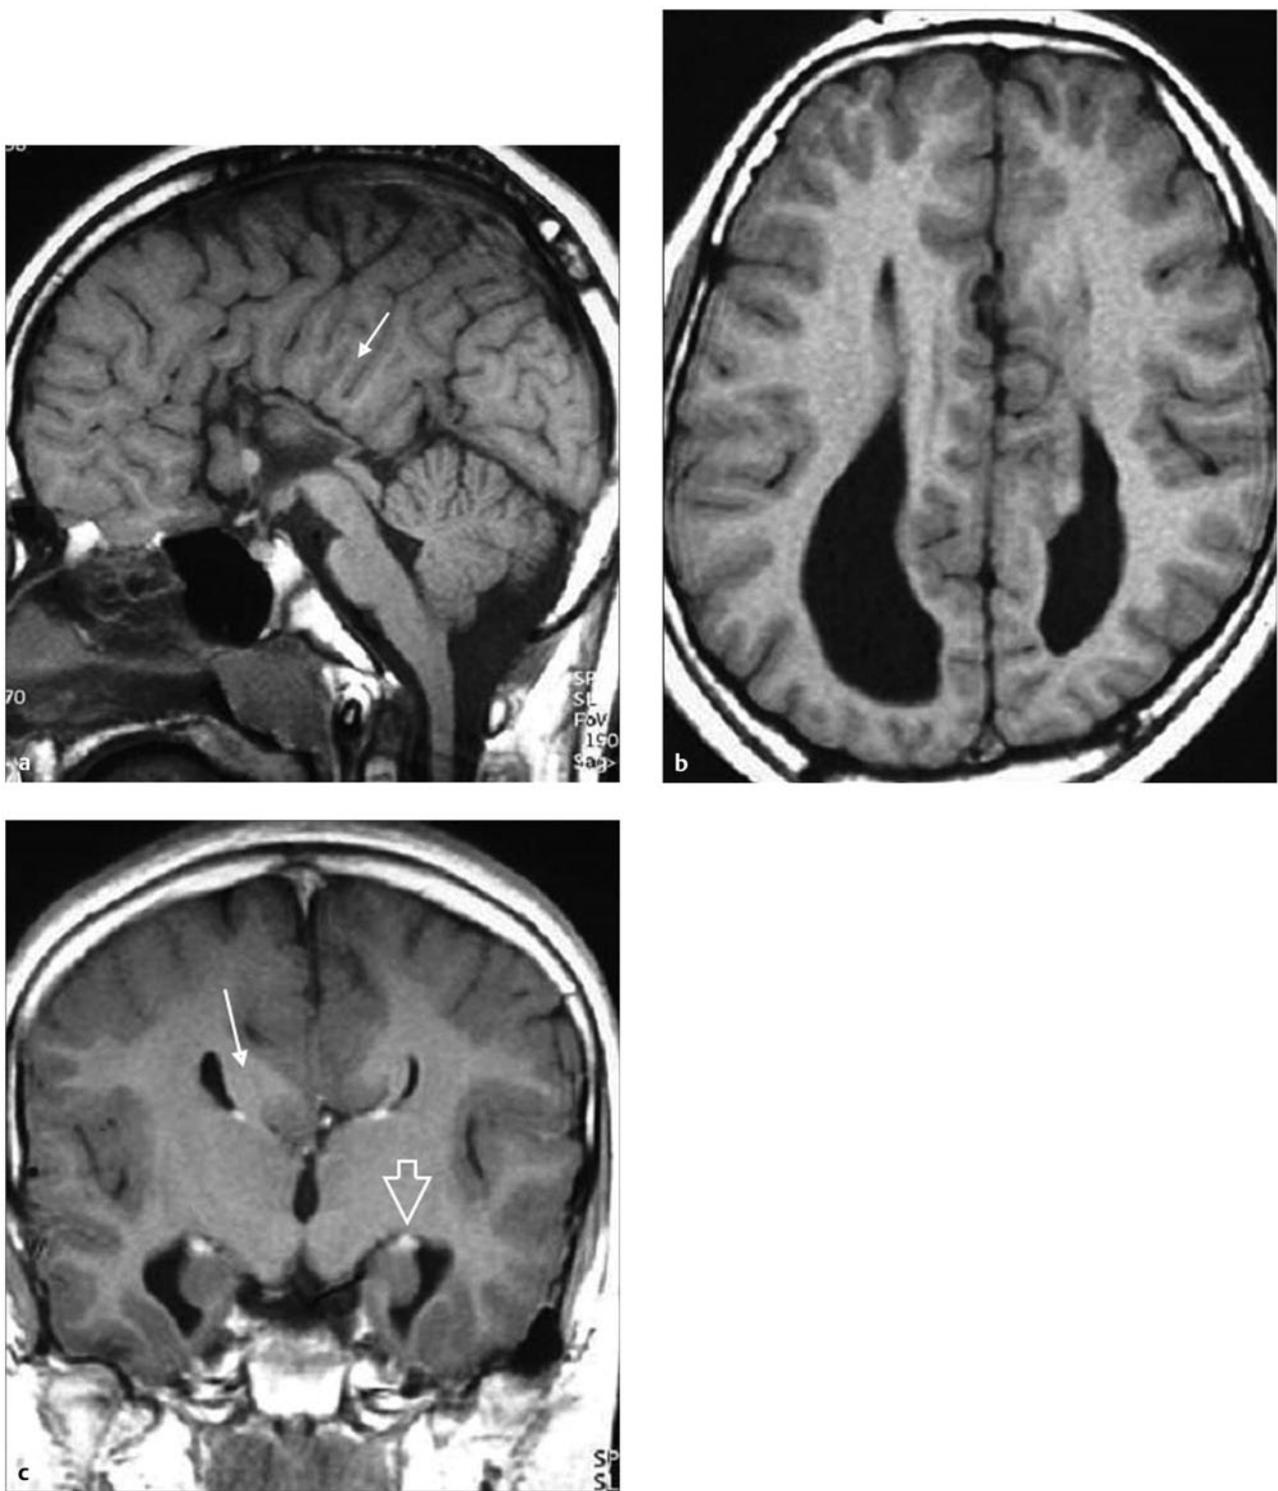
Dysgenesis of the corpus callosum. (a) Midsagittal T1-weighted magnetic resonance (MR) image shows absence of the body, splenium, and rostrum of the corpus callosum. The interhemispheric gyri are oriented radially (*arrow*). (b) Axial T1-weighted MR image shows widely separated and parallel lateral ventricles. The frontal horns are pointed and the occipital horns dilated (colpocephaly). (c) Coronal T1-weighted MR image shows agenesis of the corpus callosum and Probst bundle (*arrow*) indenting the medial surface of the lateral ventricles, resembling a “moose head.” Associated malformations include vertical orientation of the hippocampus (*open arrow*) and distortion of the temporal horn.
